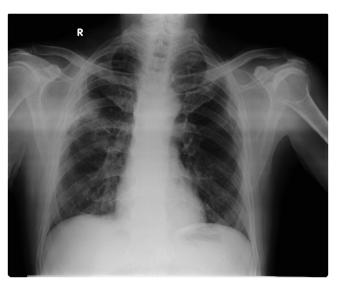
Repeat chest X-ray during follow up shows resolution of cavities.
